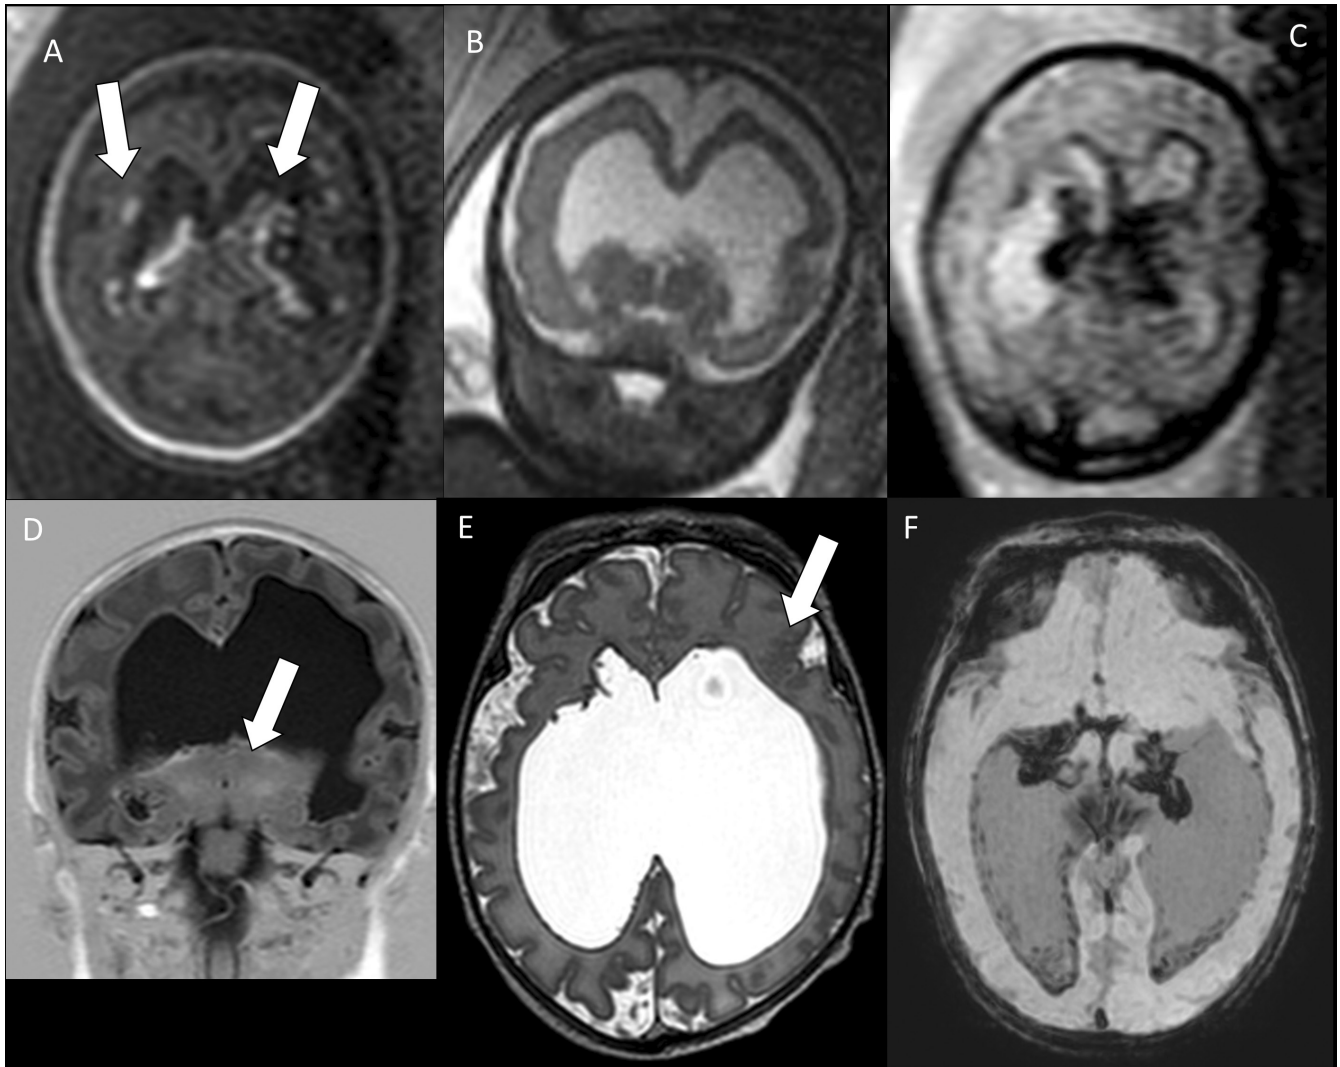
30+ 3-wk-old female fetus with intracranial in utero hemorrhage, fetal MRI (A-C). Preterm infant girl aged 3 d (same child as in fetal imaging), postnatal MRI (D-F). Axial T1 sequence on the brain shows hyperintense periventricular and choroidal plexus hemorrhage (A, arrows). Coronal T2-weighted sequence demonstrate lateral ventricles dilatation and septum pellucidum fenestration (B). Axial echoplanar sequence demonstrates hemorrhage with increased susceptibility artifacts (C). IR T1-weighted coronal scan shows progressive hydrocephalus, partial thalamic fusion (arrow) and septum pellucidum fenestration (D). Axial T2-weighted sequence with focal polymicrogyria (arrow) and septum pellucidum fenestration (E). Axial susceptibility weighted sequence demonstrates hypointense ventricular and choroidal plexus hemorrhage (F).
